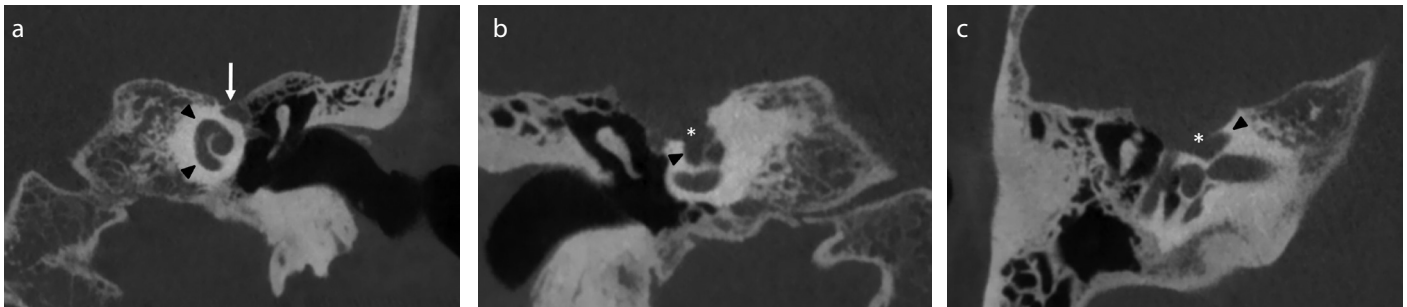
a-c. (a) Reformatted coronal CBCT reformation at the level of the geniculate ganglion on the left side. Note the normal size of the geniculate ganglion (arrow) and the distinctly separated cochlea (arrowheads). (b) Reformatted coronal CBCT reformation at the level of the basal turn of the cochlea on the right side. Sharply delineated erosion (asterisk) at the region of the geniculate ganglion in open communication with the middle turn of the cochlea. The arrowhead indicates the apical turn of the cochlea. (c) Reformatted axial CBCT at the level of the upper part of the second turn of the cochlea (arrowhead) on the right side, demonstrating the erosive lesion (asterisk) between the geniculate ganglion and the cochlea.
